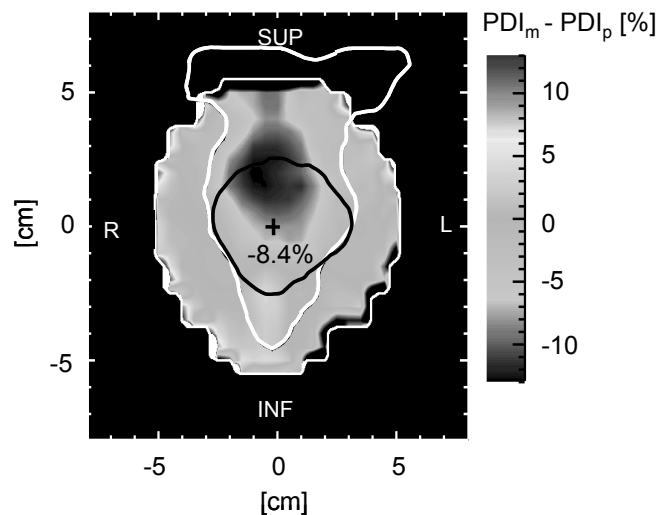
2D difference map between the measured PDI (PDI_m) and the predicted PDI (PDI_p) of a rectum cancer patient. The cross indicates the diode measurement performed for the same patient. The white and the black contour represent the rectum and the gross tumour volume, respectively, as delineated in the planning CT scan.
